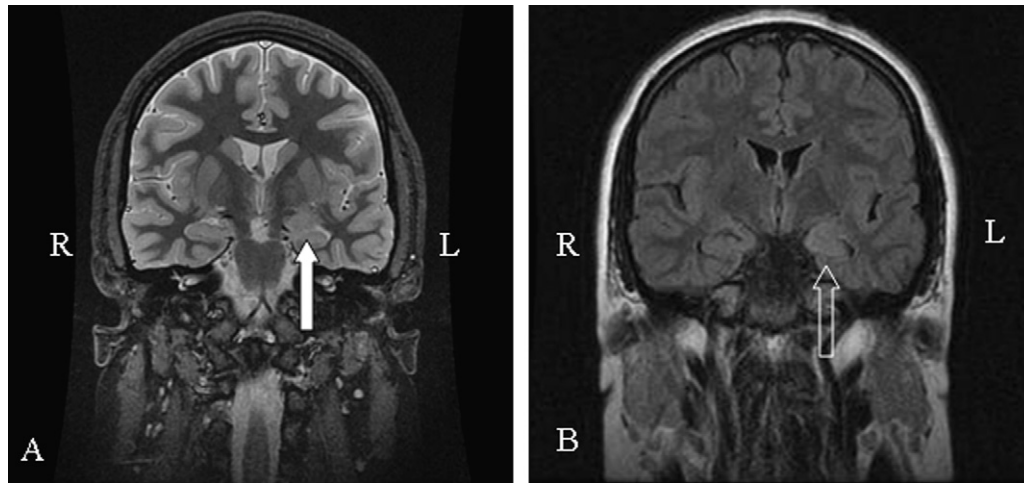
Coronal T₂-weighted (A) and coronal FLAIR (B) anatomical cranial MRI shows increased signal intensity in the left hippocampus (arrows).
